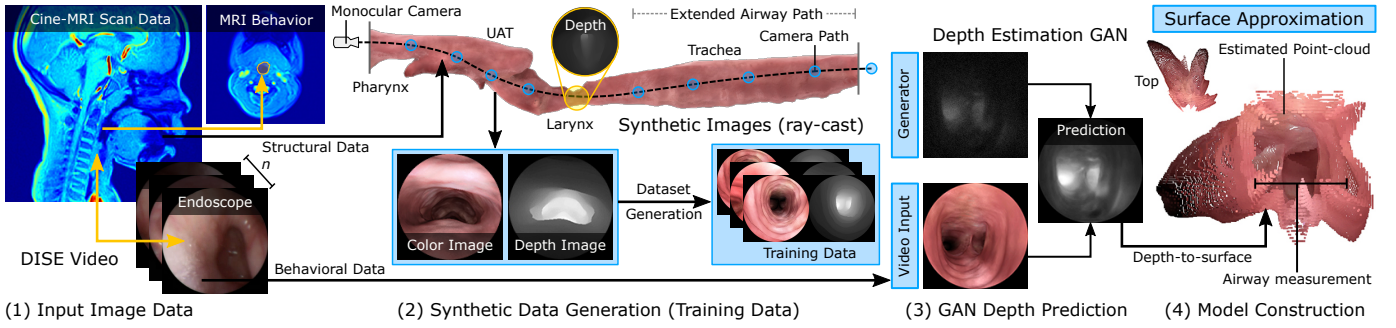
Method overview. We obtain Cine-MRI data correlated with DISE video to model dynamic airway behaviors. Synthesized data is generated to train a GAN on DISE images to generate depth images of the airway for surface reconstruction. Dynamic behaviors can then be measured using the predictions.
